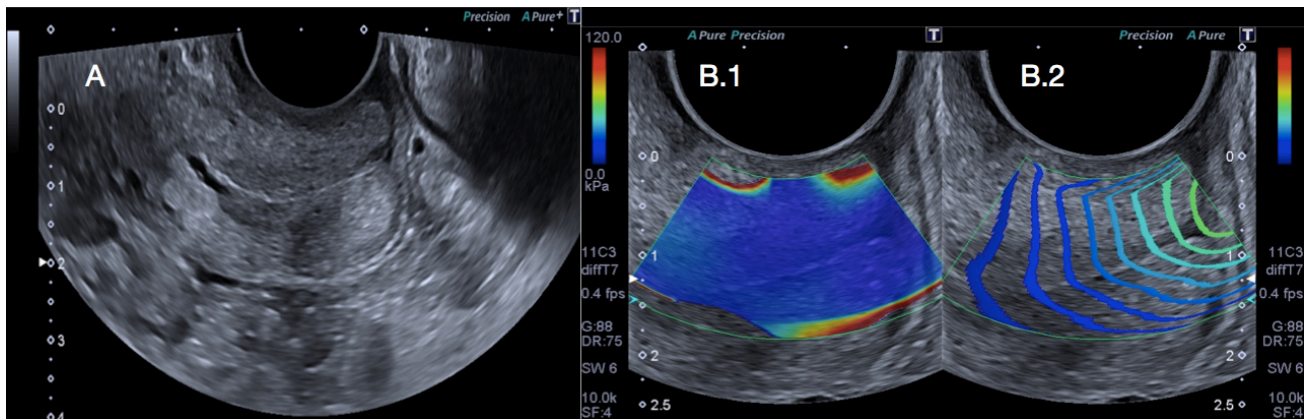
Ultrasound image of the uterine cervix in B-mode and SWE. (A) Sagittal section of the uterine cervix in mode (B). (B.1) Shear wave elastography (SWE) of the uterine cervix. (B.2) Parallel lines are required in the study area in the wave front propagation map.
